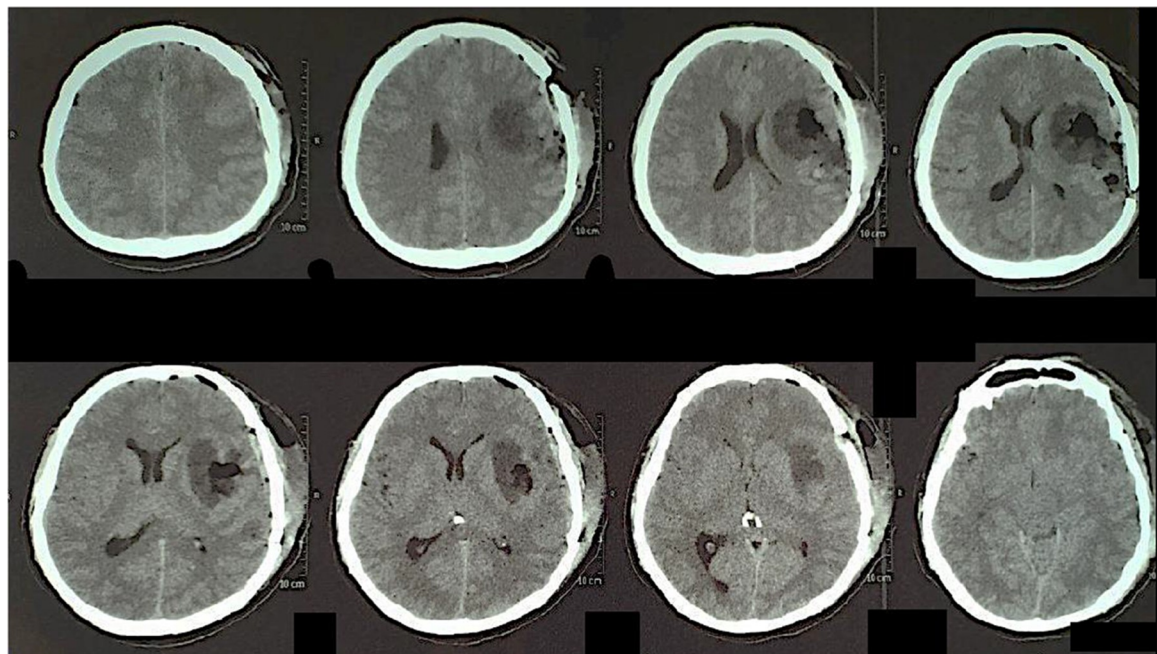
Immediate postoperative computed tomography depicting left insular tumor partial resection and slight peri-insular ischemia and local edema.
